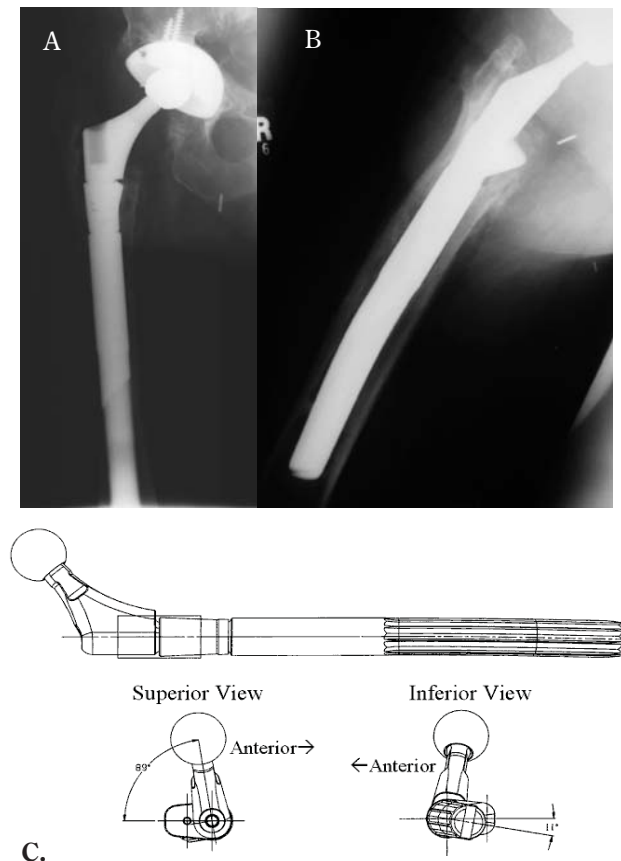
A/P radiograph (A), lateral radiograph (B) and corresponding model (C) depicting implantation with metaphyseal segment seated in marked retroversion and distal stem segment in standard position. Metaphysis is rotated 89° from neck centerline and now faces nearly straight posterior in 78° of retroversion. The stem apex faces 4° lateral of straight anterior.
